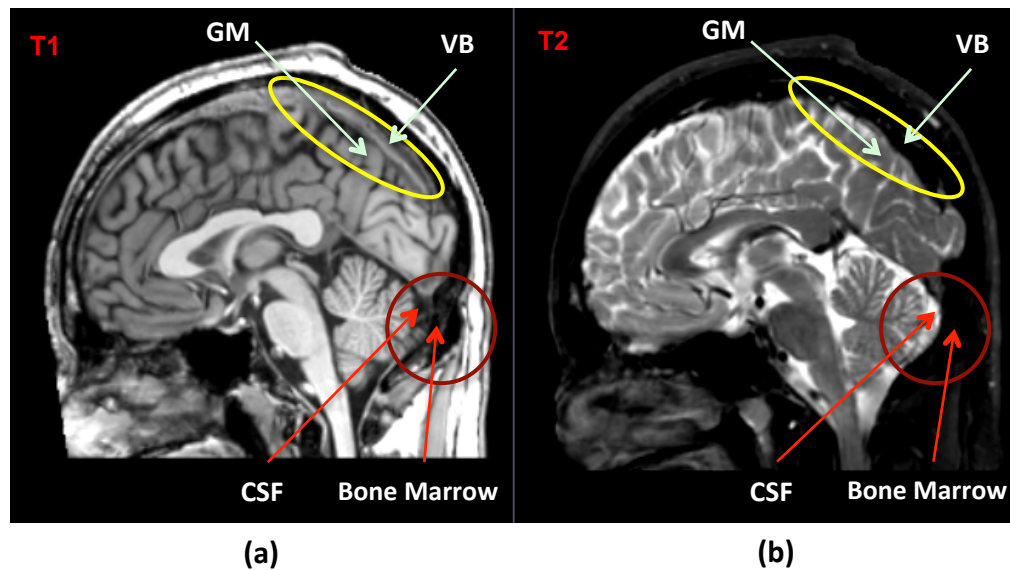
(a) It is hard to distinguish between gray matter (GM) and venous blood (VB) (as both are shown as grey) and to distinguish CSF from the bone marrow (since both are shown as dark) by looking only at T1-weighted MR scan. (b) T2-weighted MR provides better contrast in the case of T1 ambiguities between mentioned tissue types, since here GM is gray but VB is dark; also CSF is shown as white while bone marrow is dark.
